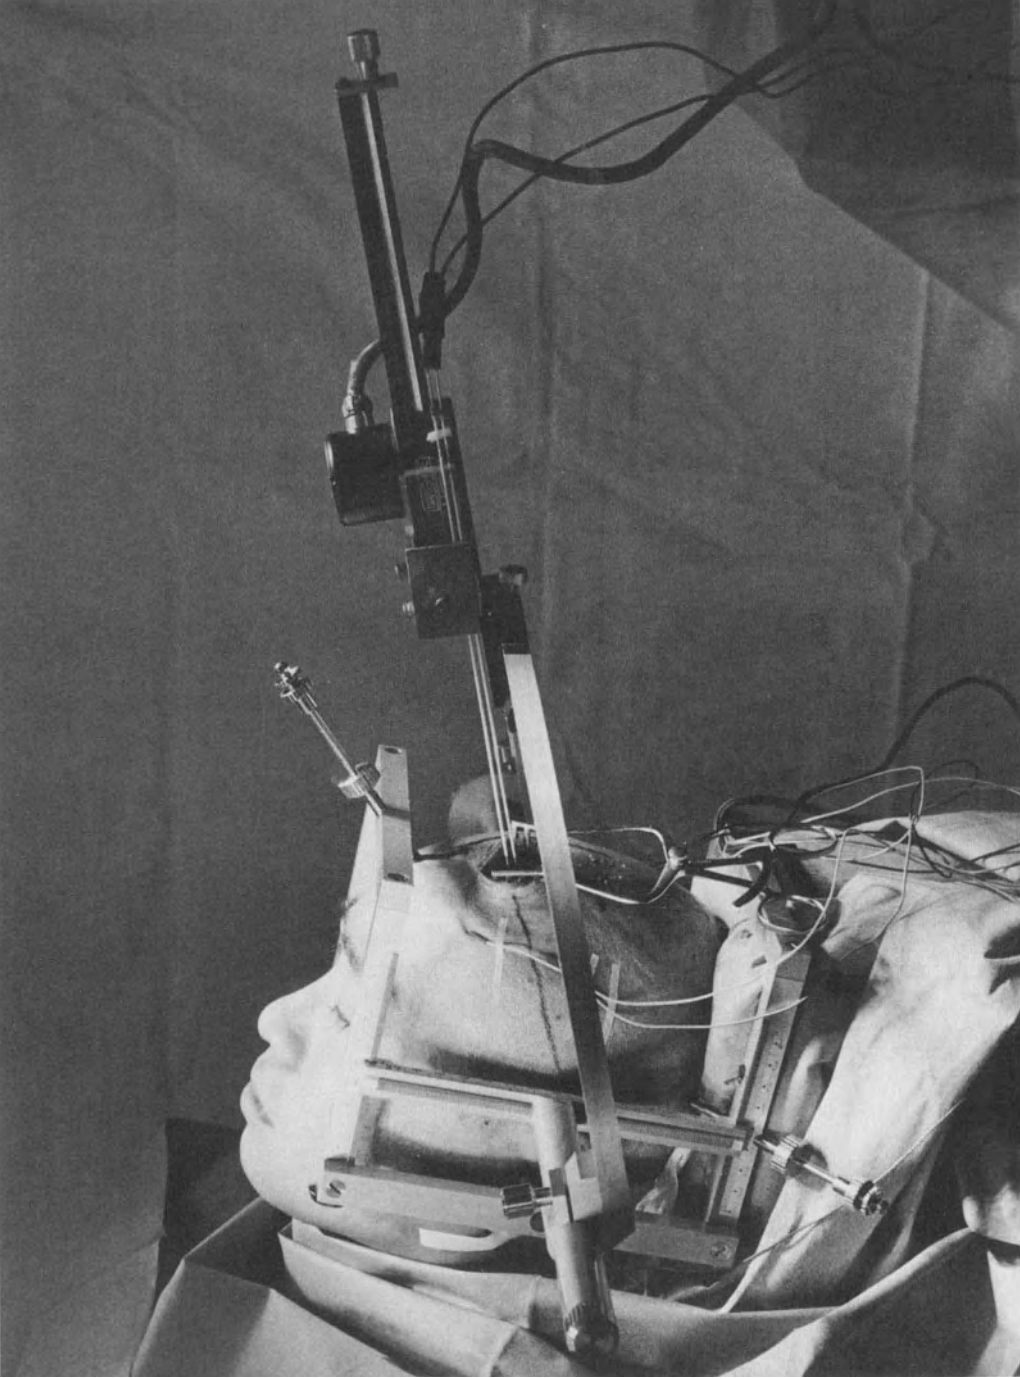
Stereotactic instrument fixed on a patient's skull. The semicircular arc is set at the same angle as that of the stereotactic CT scan (indicated by a line on the scalp). Note that a burr hole is opened on this line. A pair of recording electrodes will be introduced into the brain with the aid of a micromanipulator.
